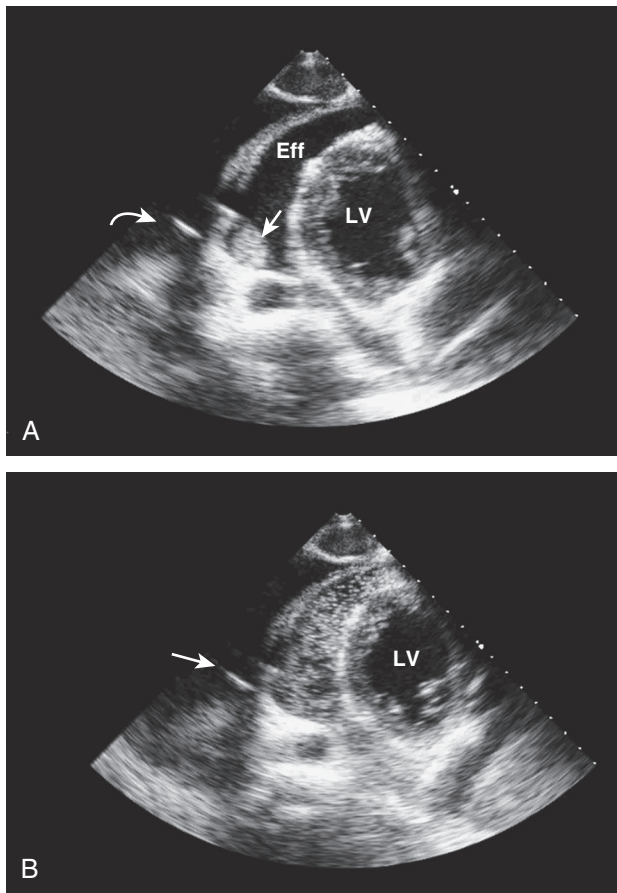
Echocardiographic images from a patient with effusive-constrictive disease. A, Tamponade. *Curved arrow* points to needle in pericardial space; *straight arrow* points to tumor mass. The pericardium is thickened. B, Agitated saline has been injected through the needle (*arrow*) to confirm entry into the pericardial space. Eff, effusion; LV, left ventricle.
